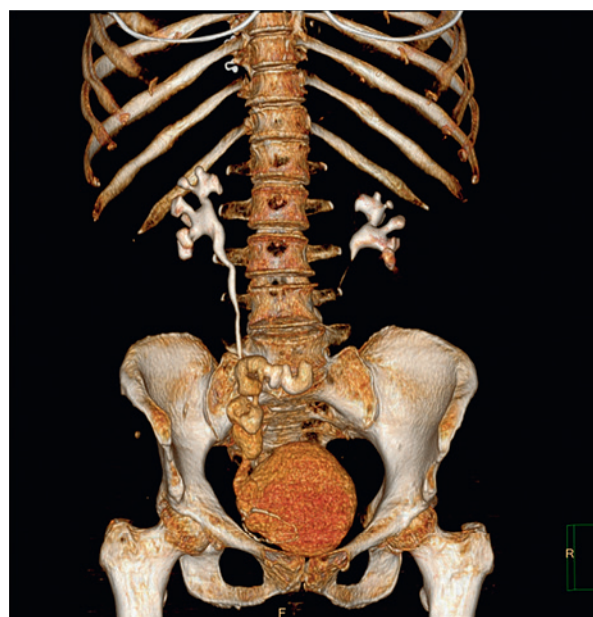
CT after 1 year. No impairments of urine passage were detected
